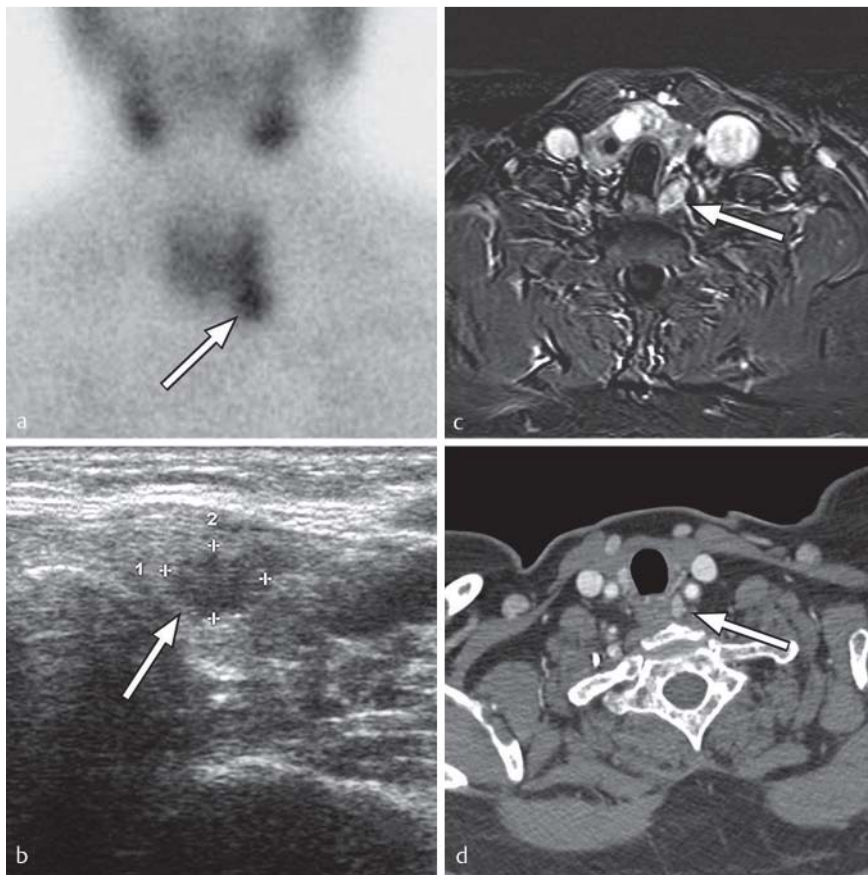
Positive findings of parathyroid adenomas (arrows) in a Scintigraphy, b Ultrasound, c MRI, d CT.
